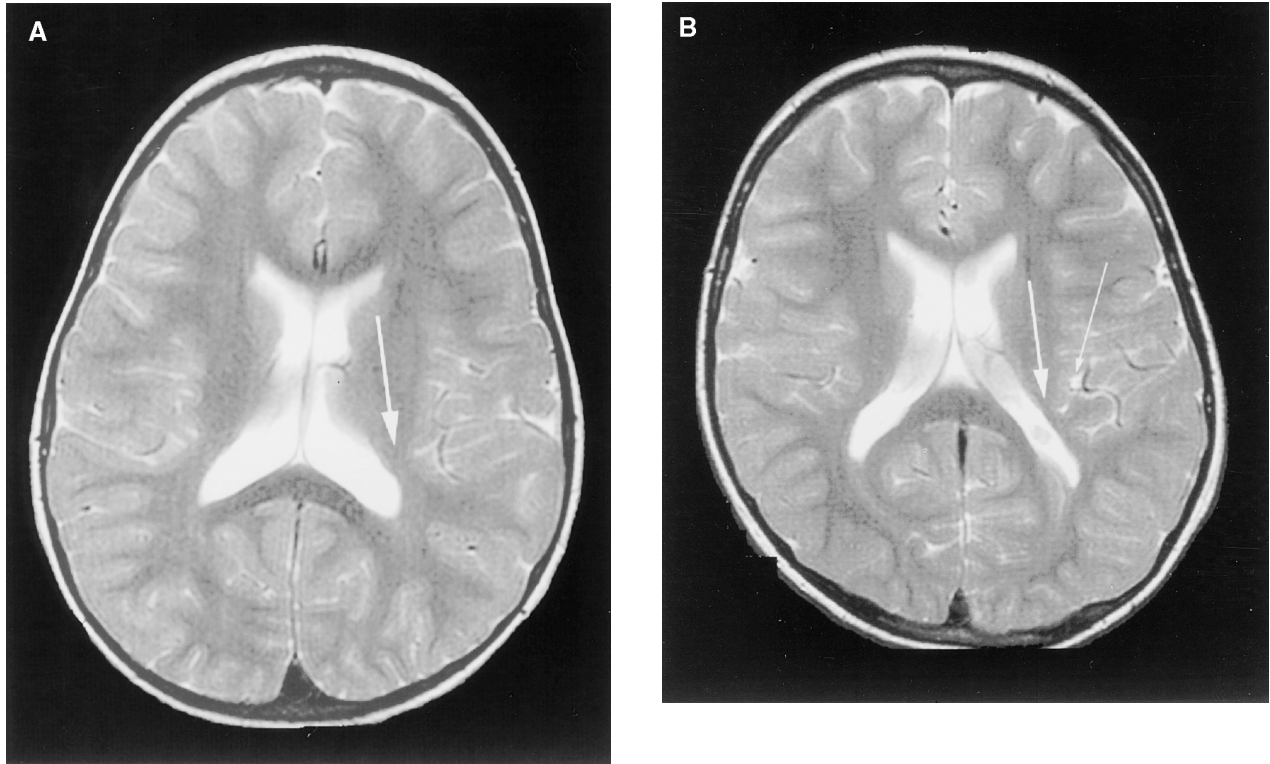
A: This MR image, taken from a 4 1/2-year-old girl with a posterior fossa primary brain tumor, shows the normal amount of periventricular white matter (arrow) that should be expected in a child of this age (T2-weighted image). B: This is the MRI of a 5-year-old girl born prematurely, who had mild spastic diplegia with slight right-sided dominance. Note the reduced amount of periventricular white matter seen bilaterally but most pronounced on the left side (thick arrow). Also note dilatation of the deep portions of left Sylvian fissure (thin arrow). This finding is consistent with mild PVL (T2-weighted image). (Courtesy of Dr. Olof Flodmark.)
